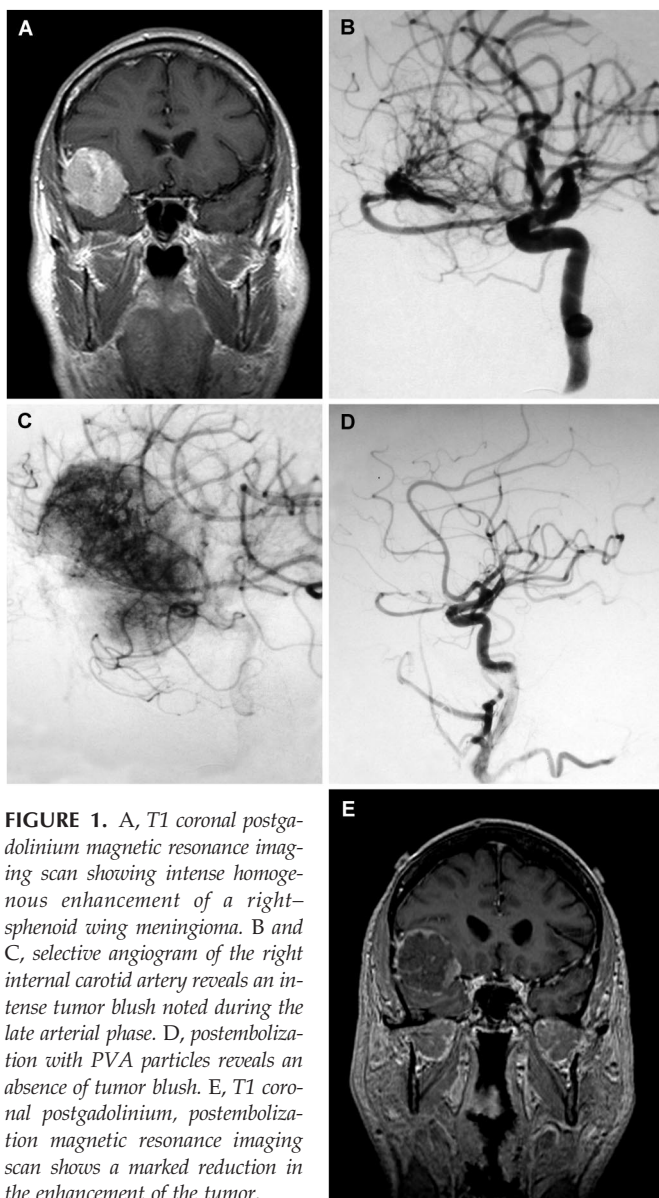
A, T1 coronal postgadolinium magnetic resonance imaging scan showing intense homogeneous enhancement of a right-sphenoid wing meningioma. B and C, selective angiogram of the right internal carotid artery reveals an intense tumor blush noted during the late arterial phase. D, postembolization with PVA particles reveals an absence of tumor blush. E, T1 coronal postgadolinium, postembolization magnetic resonance imaging scan shows a marked reduction in the enhancement of the tumor.
